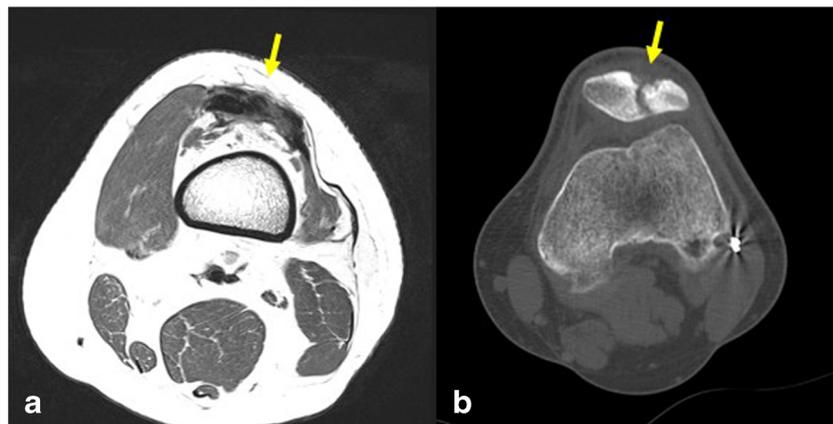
Patellar fracture following QTB graft harvesting, a complication that can occur if harvesting of bone block is too deep or to lateral. a Axial T1 MRI showing that the harvest of the quadriceps tendon is lateral. b Axial CT image showing fracture of the patella after quadriceps tendon
